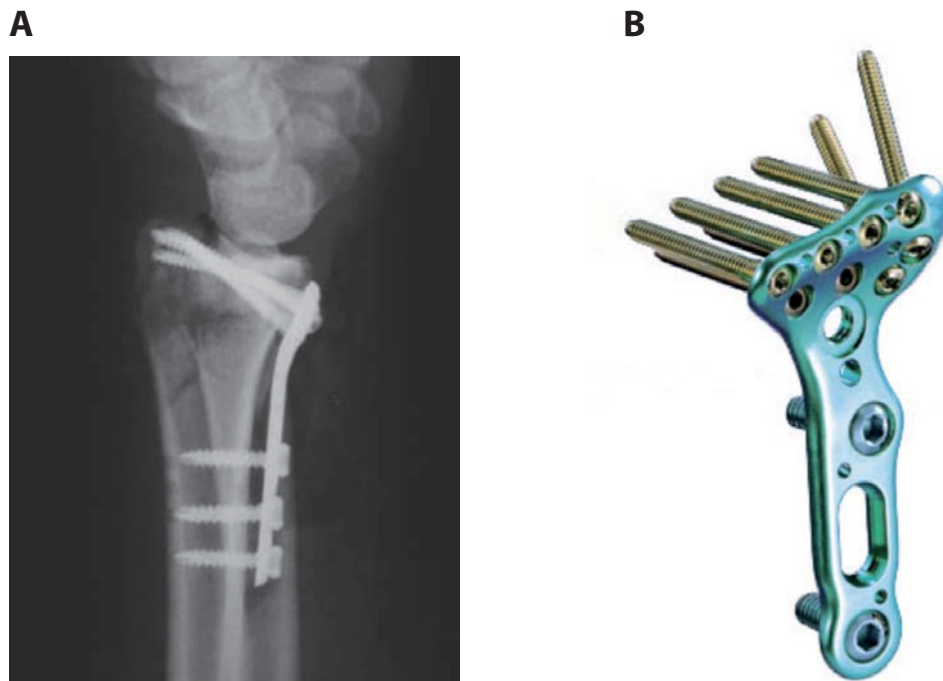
A post-operative radiographic image of a fracture stabilized with a fixed-angle palmar plate (A) and an image of a palmar plate (B).
